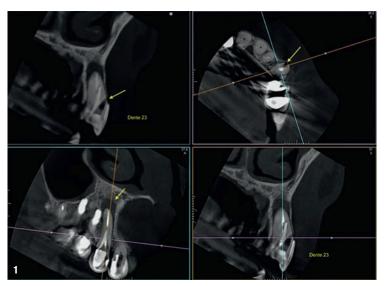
A CBCT scan was performed for diagnosis and to establish a treatment plan.
